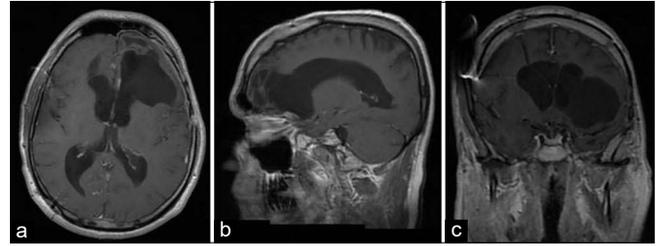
Postoperative brain magnetic resonance imaging showing large area of structural alteration, consisting predominantly of cerebrospinal fluid and a tissue portion with calcifications. (a) axial plane, (b) sagittal plane, (c) coronal plane.
